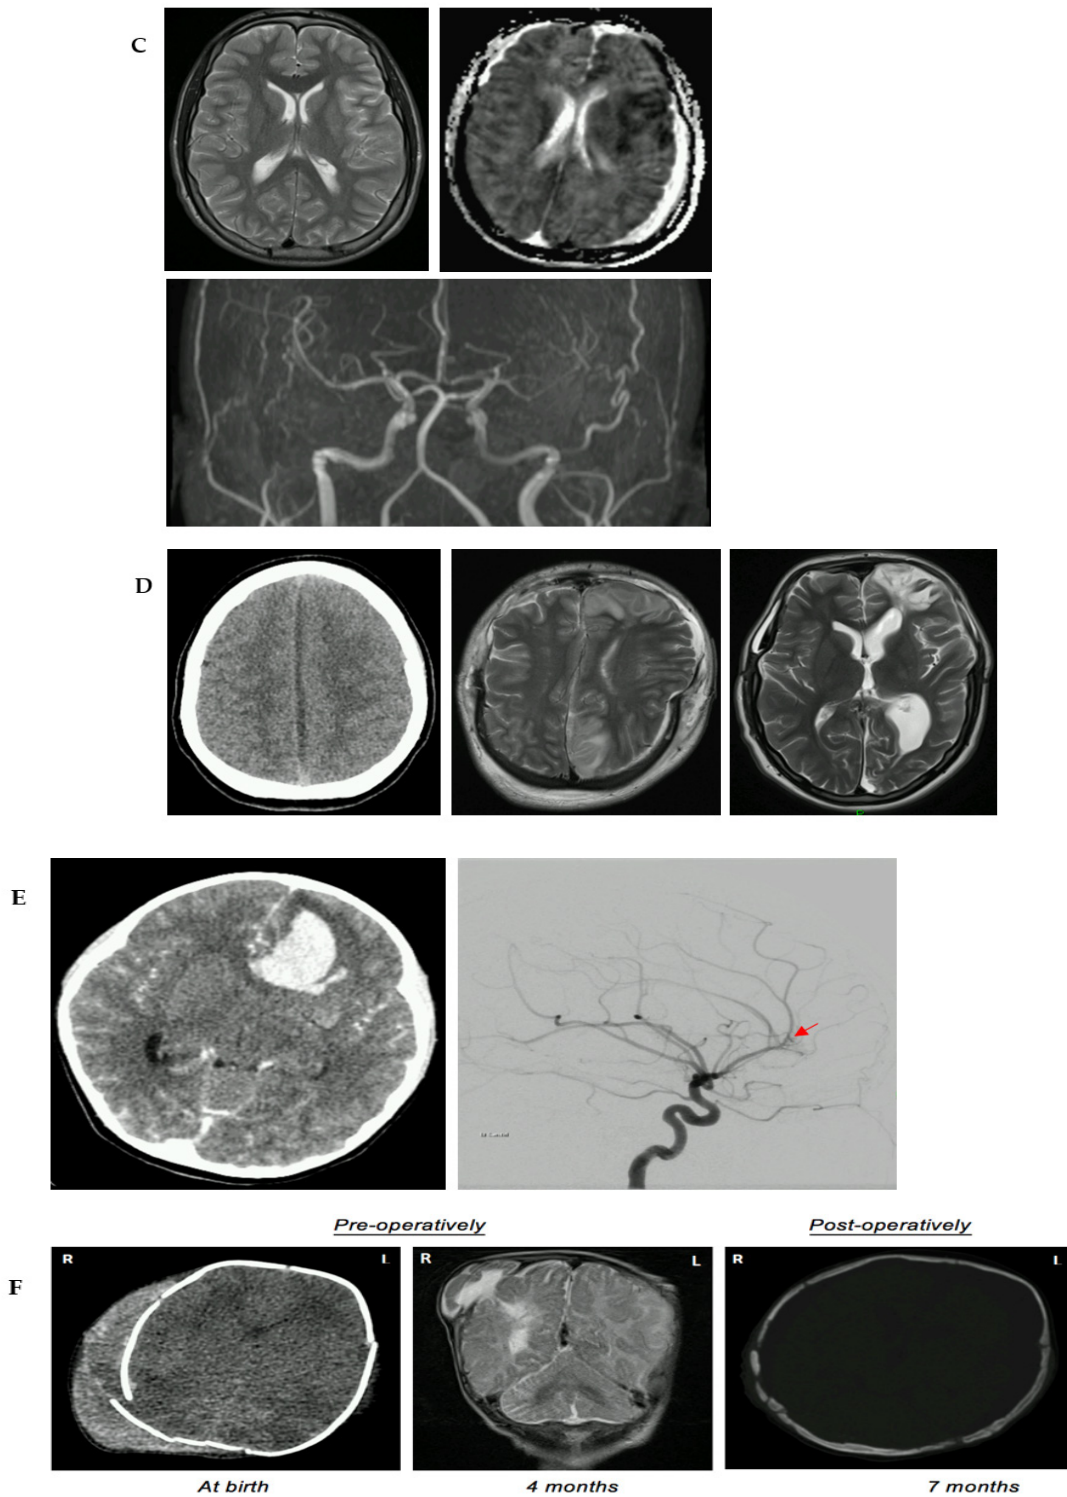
A) T2-weighted (left) and diffusion-weighted (right; DWI) axial MRI images showing areas of cerebral oedema and diffusion restriction mainly in the left hemisphere. B) Initial CT scan on the left which was normal, an MRI in the centre following a decline in GCS showing a right frontal haemorrhage. Given the case this was considered a haemorrhagic transformation from an infarct due to septic emboli. On the right-hand side is the post-operative CT showing good decompression of the clot. C) T2-weighted and DWI axial MRI images (left and right respectively) showing a right-sided MCA territory infarct (restriction on DWI). The MR angiogram below shows evidence of ICA dissection. D) Initial CT (left) showing a parafalcine collection and T2-weighted MRI following craniectomy and washout (centre). The right-hand side image is the most recent MRI following cranioplasty. E) Initial CT axial image for Case 5 showing a left frontal intra-parenchymal haemorrhage and midline shift requiring emergency craniotomy and evacuation. The digital subtraction angiogram on the right shows the diffuse micro AVM (red arrow) where the ACA bifurcates into the pericallosal and callosomarginal arteries. F) Initial CT axial image on the day of birth for Case 6 showing a complex right parieto-occipital fracture and associated subgaleal collection. The centre image (coronal T2-weighted MRI) shows herniation of the parietal lobe through the defect and associated ischaemia. The post-operative CT shows bony windows following repair of the dura and cranium.
